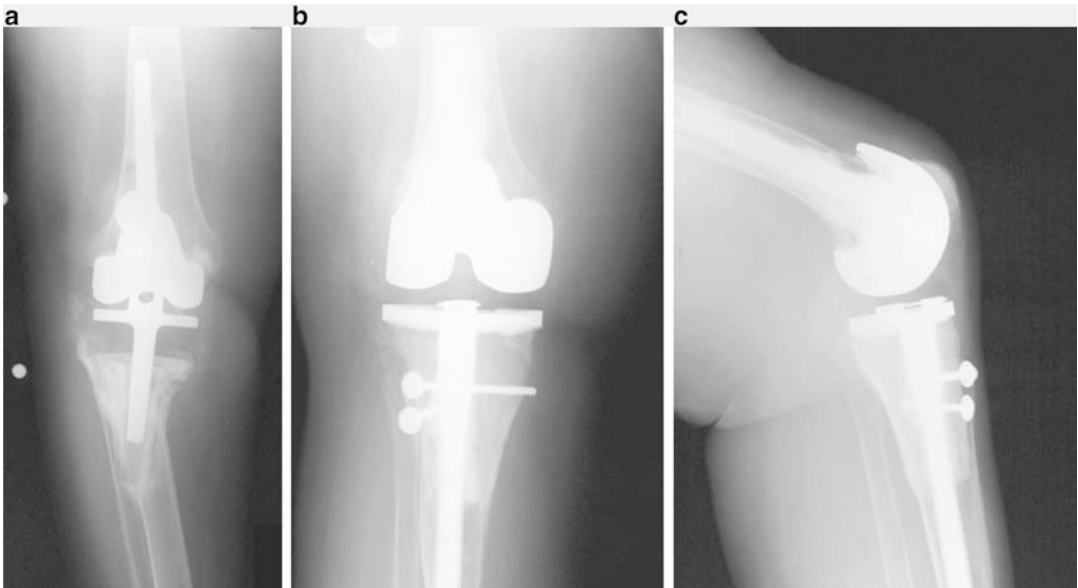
(a) Failed, infected total knee arthroplasty demonstrating severe tibial and femoral bone loss. (b and c) Postoperative radiographs taken 3 years after revision using
